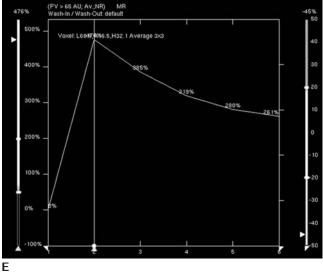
(*Continued*) (C) Axial T1-weighted image pre-contrast. Low signal intensity of breast cancer (*double headed arrow*). Bright signal of hematoma (*arrow*). (D) Axial T1-weighted image immediately following contrast bolus. Cancer enhances (cursor placed for kinetic curve evaluation), hematoma demonstrates a small amount of delayed enhancement. (E) Mass (see cursor position in D) characterized by rapid initial enhancement and wash out of contrast consistent with malignancy.
